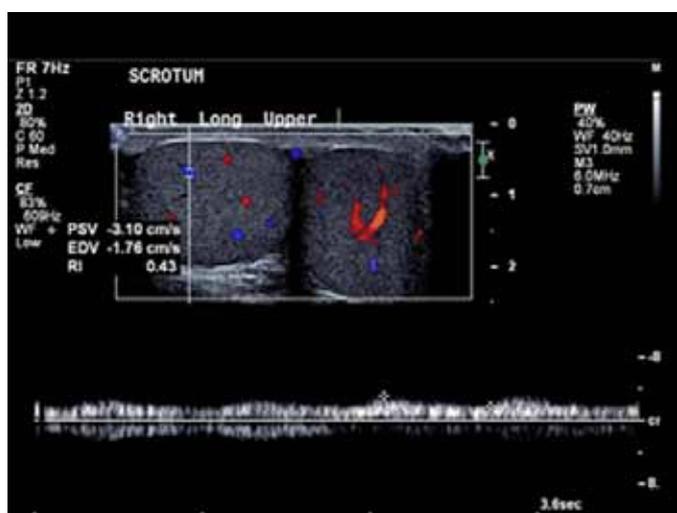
Right upper testis with normal Doppler flow and dimensions (2.3x2.6 cm).
